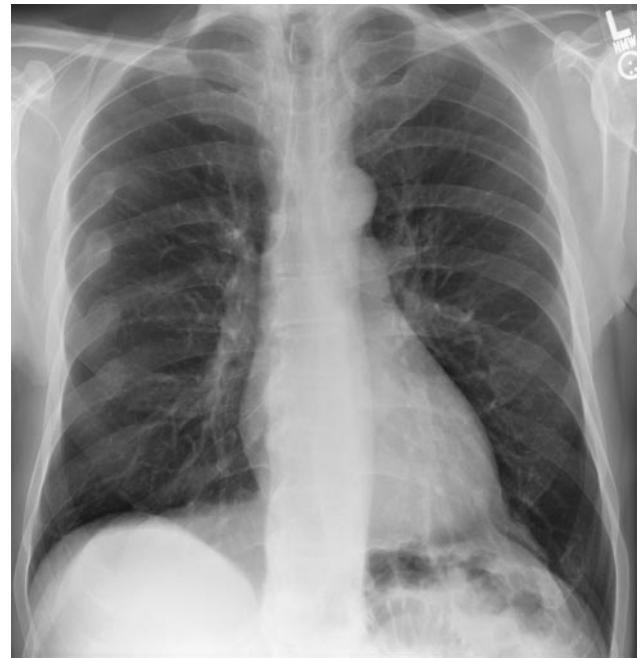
Repeat chest radiograph shows resolution.
